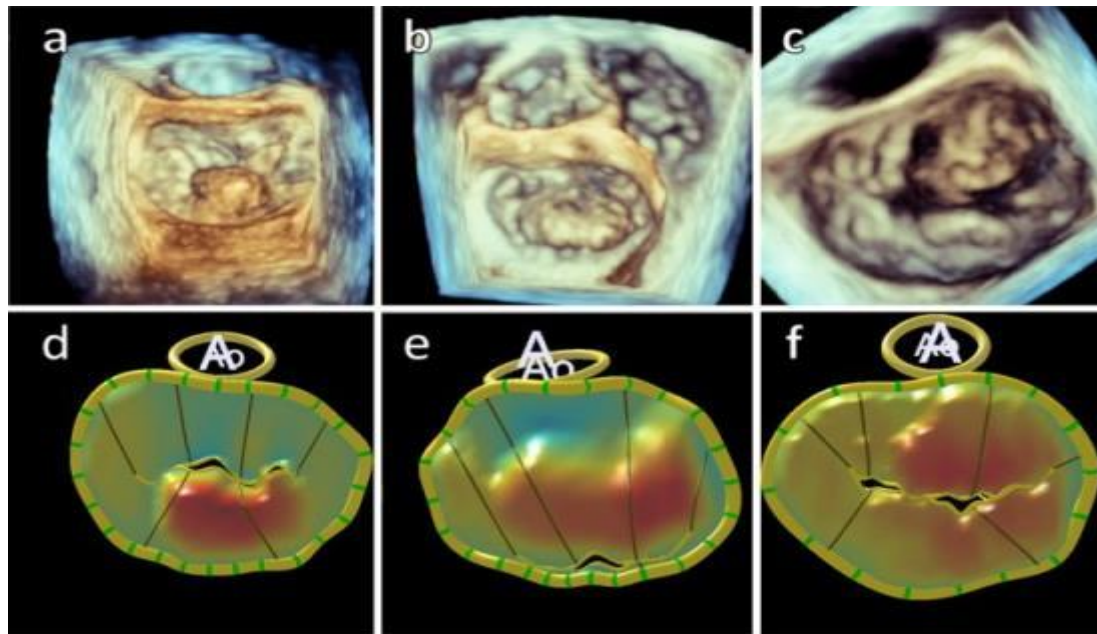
Localization of mitral valve prolapse. Panels a, c, and e show 3D echocardiographic images, and b, d, and f are their 3D modeling. Panels a and b are posterior, c and d are anterior, and e and f are bileaflet prolapse, respectively (5).
